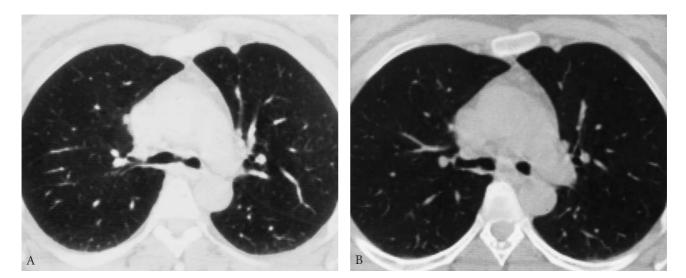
Wegener's granulomatosis of the main bronchi. Computed tomography scans through the main bronchi reveal diffuse nodularity of the bronchial walls.
